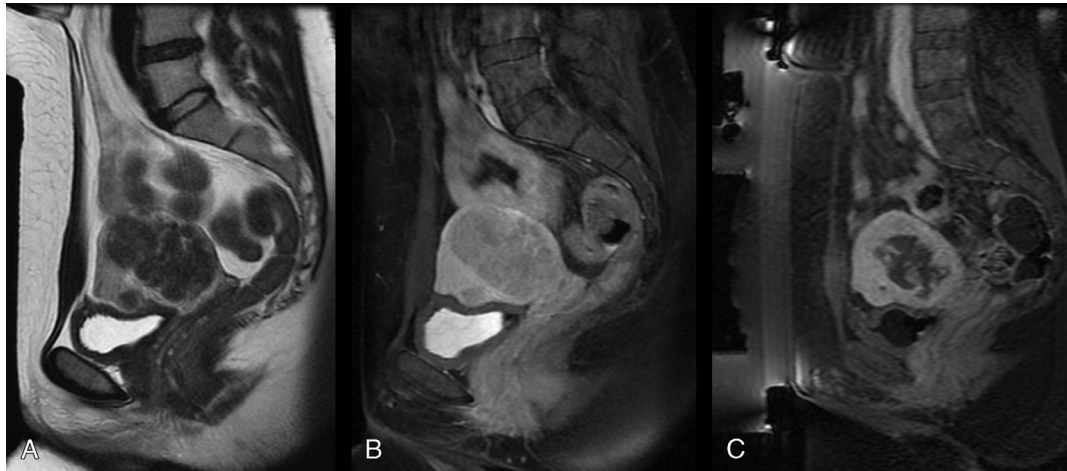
A 34-year-old woman with 75 cm³ of fibroid tissue experiencing hypermenorrhea. A, Sagittal T2w MR image obtained before treatment shows several hypointense intramural fibroids. B, Sagittal contrast-enhanced fat-suppressed MR image before treatment shows a strong enhancement of the vital fibroid tissue. C, Sagittal contrast-enhanced fat-suppressed MR image acquired after treatment. Because of strong vascularity of fibroid tissue and intramyomal septations, an NPV ratio of only 51% was achieved.
